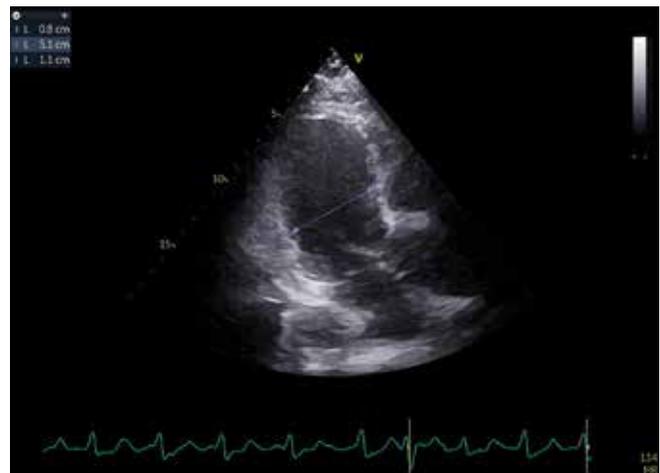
Echocardiography findings showing deterioration of LV function and ejection fraction
